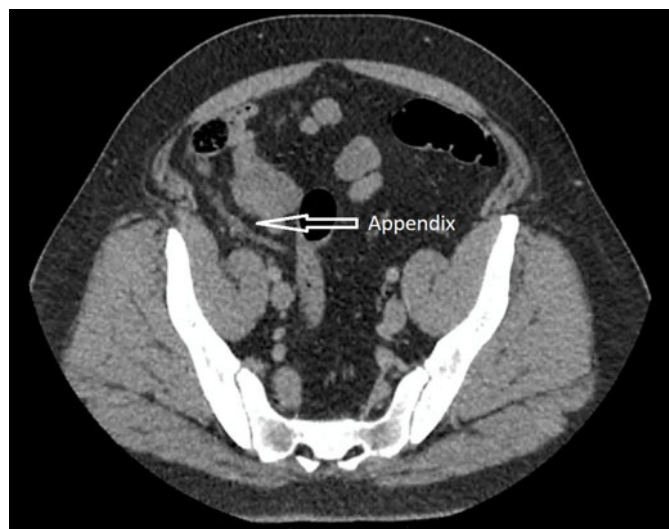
Axial view of computed tomography (CT) showing some inflammation of the appendix.
